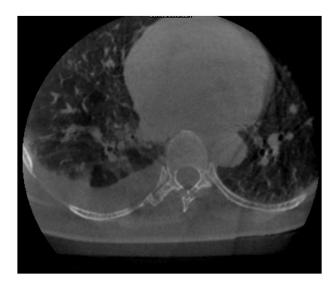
Cone beam CT of the chest demonstrating stable right hemothorax.
